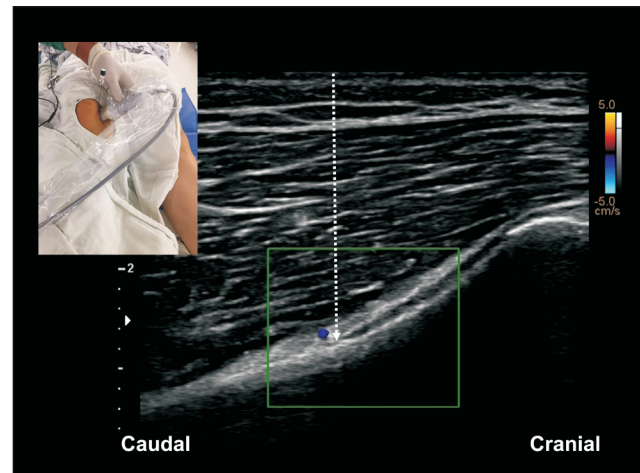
Ultrasound-guided superior medial genicular nerve block. Representative longitudinal images of the right knee at the level of the distal femoral epicondyle and medial metaphysis of femur is shown. The superior medial genicular nerves accompany each the superior medial genicular artery which is identified using color Doppler mode. Dashed arrow indicates the out-of-plane needle pathway for the superior medial genicular nerve block.
